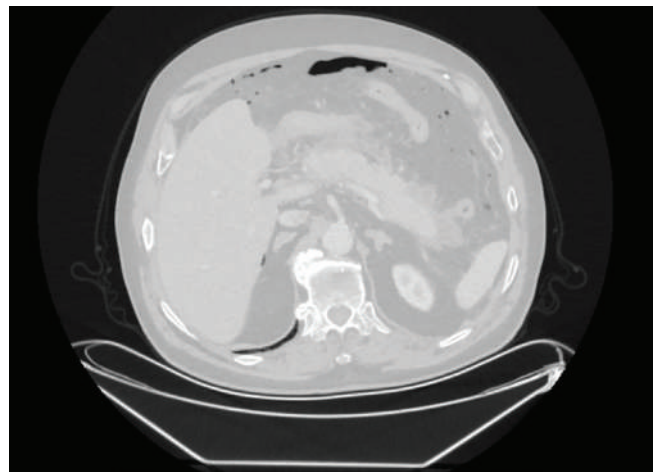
Contrast-enhanced abdominal CT demonstrating peripancreatic necrotizing collection areas and widespread free intraperitoneal air.
